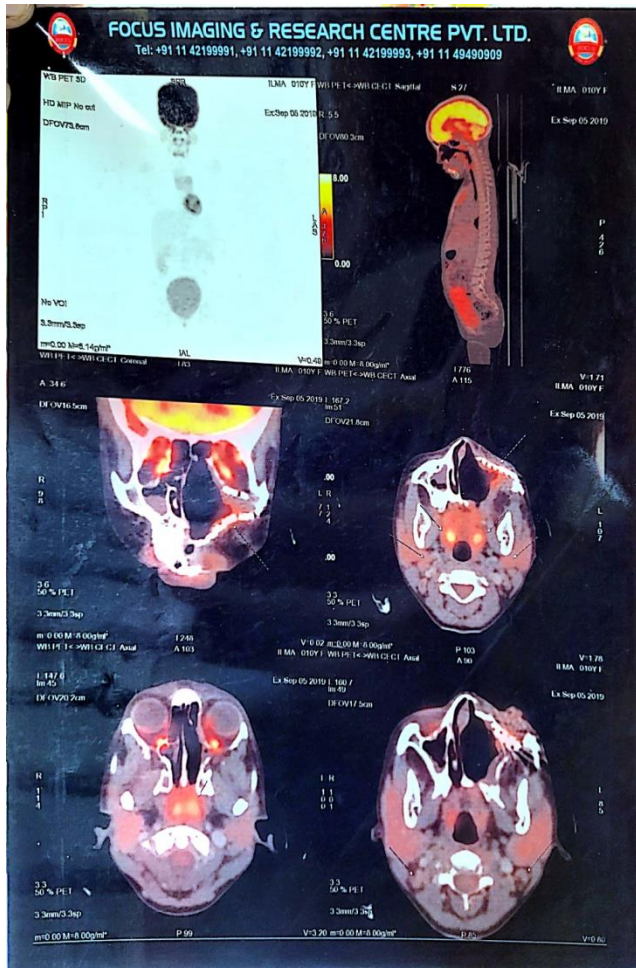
PET-CT Scan showing the primary disease area
